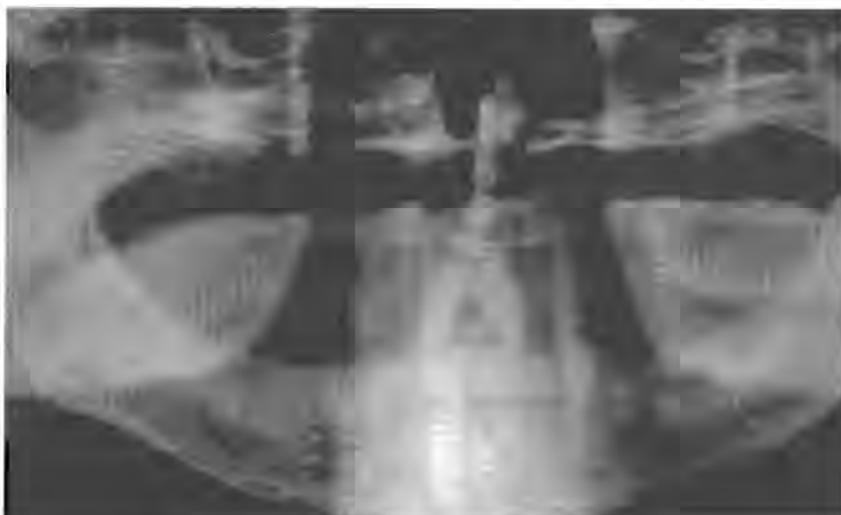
Panoramic radiographic view showing lack of bony involvement of the mandibular right alveolar ridge.
